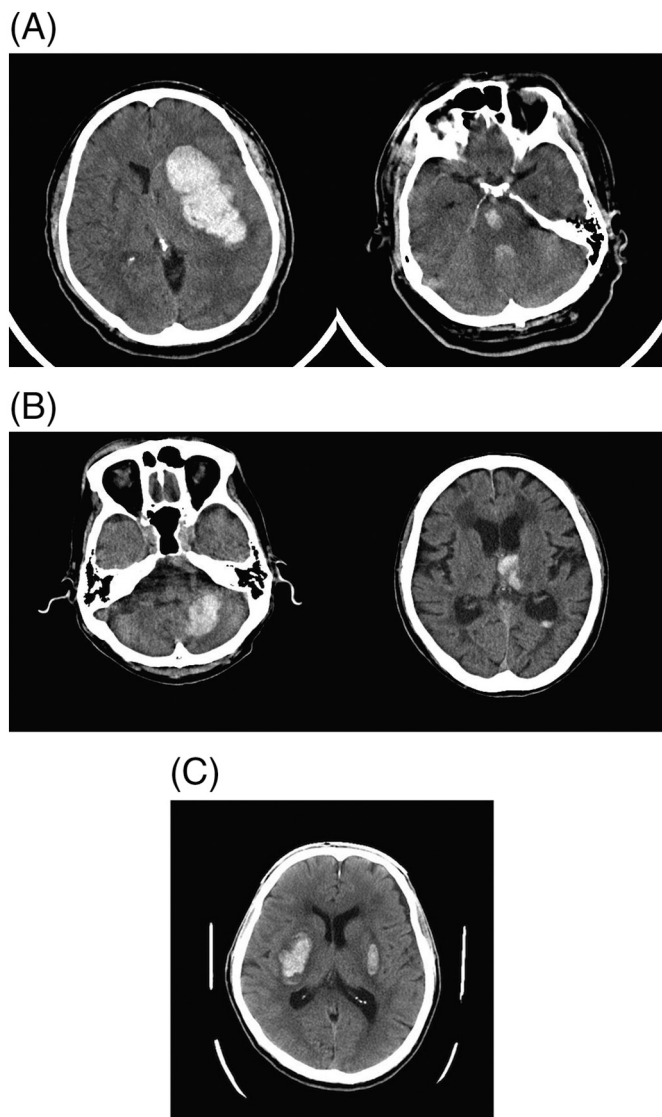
Computed Tomography (CT) scans of representative cases of multiple simultaneous intracerebral hemorrhages (MSICH). There were significant differences in size between larger and smaller hematomas.
